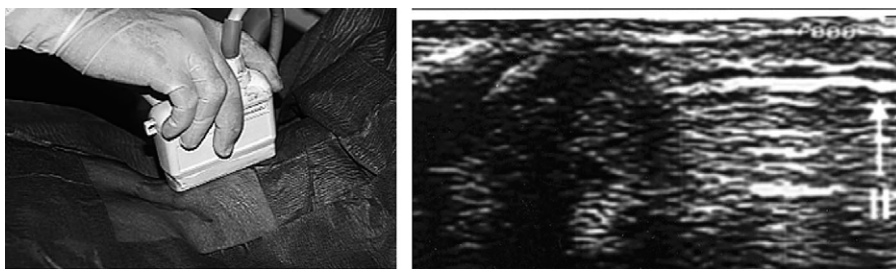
The ultrasound transducer is pulled cranially until the lower edge of transducer is placed above the tracheal ring (second ring), below which the puncture of trachea for percutaneous tracheostomy will be performed.
